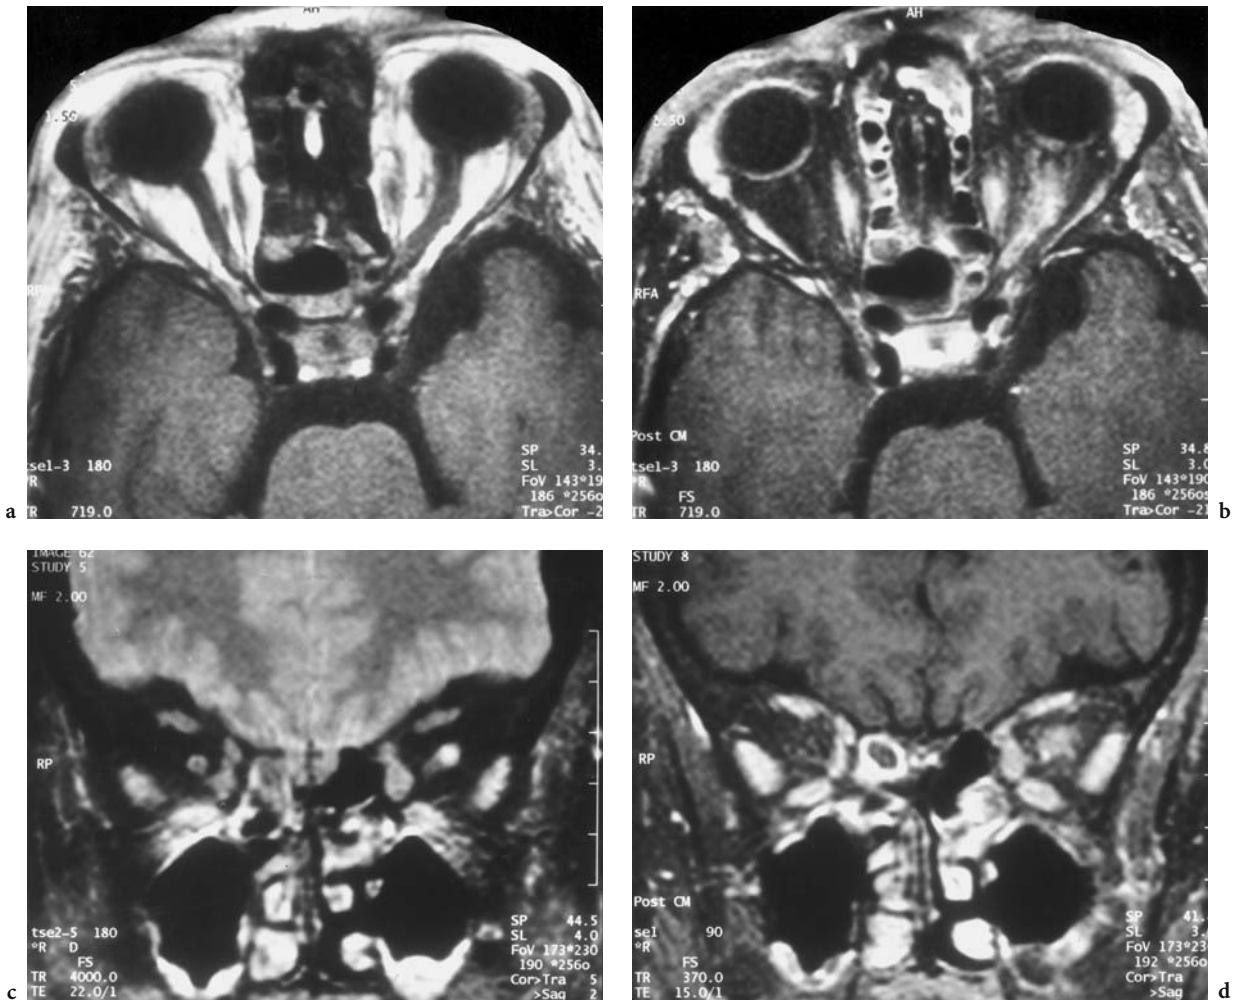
A 38-year-old woman with acute loss of vision in the left eye and a history of breast carcinoma. Cortisone therapy was successful, and nothing abnormal was detected on follow-up after 24 months; differential diagnosis of meningeal metastasis of the primary tumor is unlikely. Diagnosis: idiopathic inflammation of the left optic nerve. MRI: a Axial T1-weighted native view. b Corresponding contrast-enhanced (FS) image with irregular enhancement along the left optic nerve sheath complex. c Coronal T2-weighted view where the left optic nerve exhibits significant signal enhancement. d Corresponding T1-weighted, contrast-enhanced (FS) view with significant T1-time shortening of the left optic nerve
